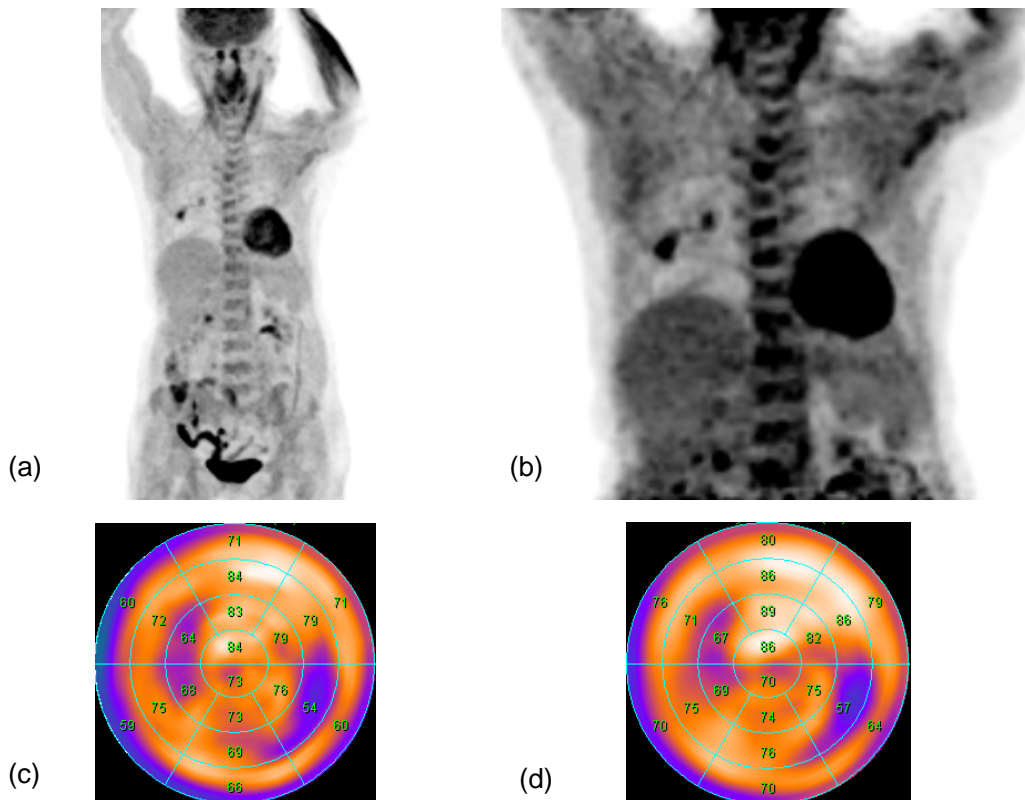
A 20-segment polar map demonstrating percentage perfusion of FDG activity in Patient B for protocol 1 (c) and protocol 2 (d)
